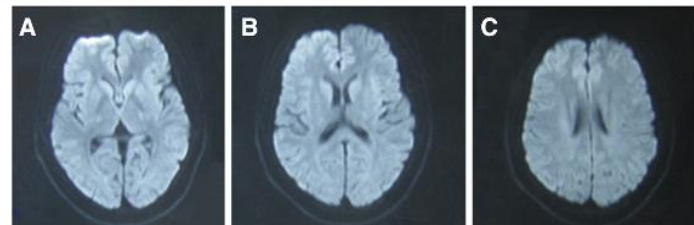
The third MRI after two months of onset. Diffusion-weighted MRI after two months of onset by which time the patient has no repeated neurological attacks, shows nearly complete resolution of the white matter changes (A, B and C).
